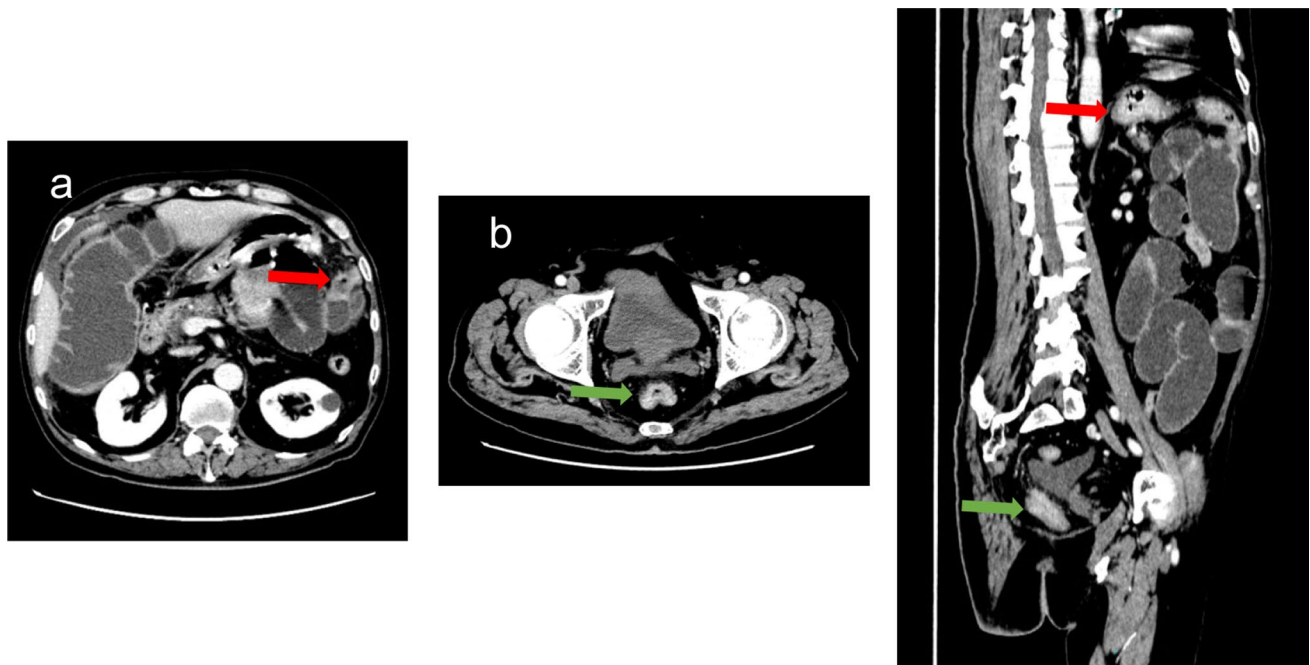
Abdominal computed tomography (CT) revealed a possible obstructive rectal tumor(green arrow) and a mass in the transverse colon(red arrow). Abdominal computed tomography (CT) imaging
